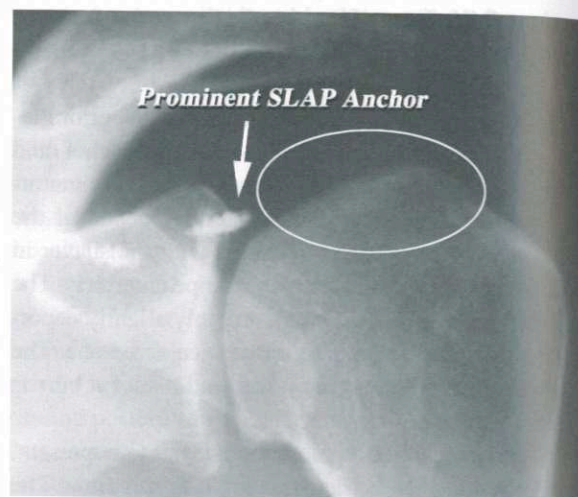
An anterior-posterior radiograph showing a proud metal SLAP anchor. The circle highlights the subsequent iatrogenic chondral and humeral head injury
